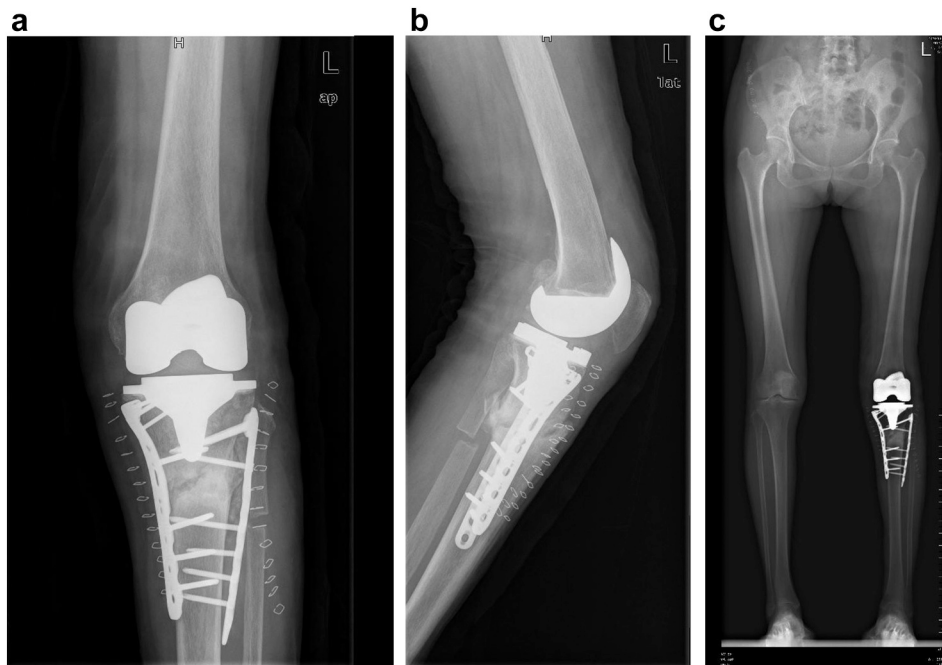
Radiographs taken 1 day after open reduction. (A) Anteroposterior view. (B) Lateral view. (C) Full-length radiograph of both lower limbs in standing position.
